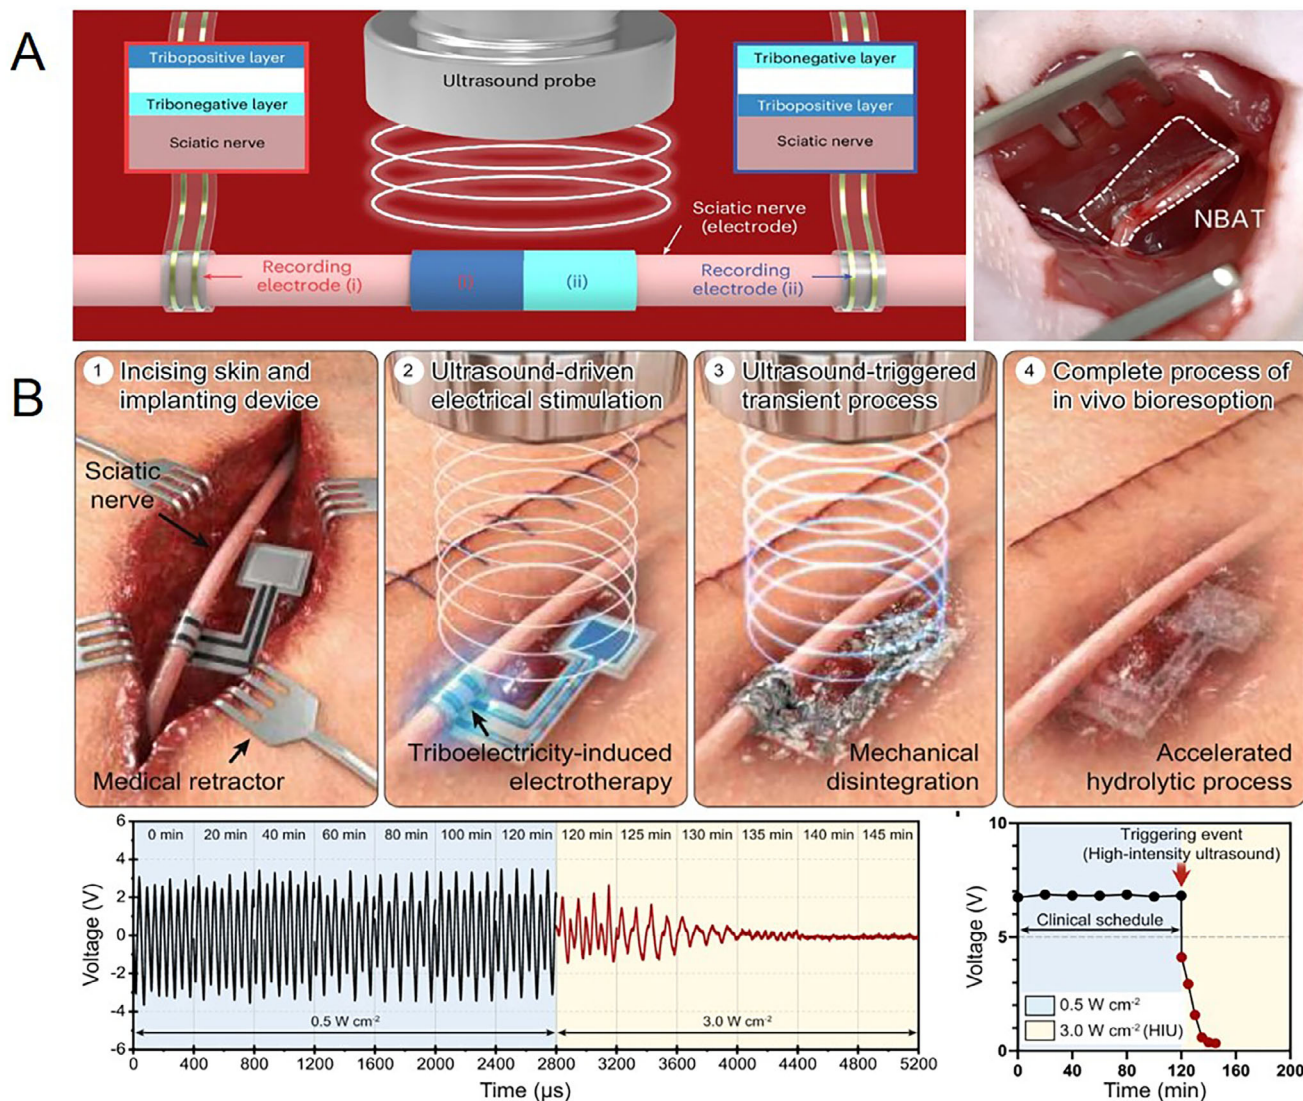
In situ therapeutic applications of implantable triboelectric systems. (a) A bioresorbable TENG that generates localized triboelectric electric fields under ultrasound stimulation for pain modulation. Reproduced with permission [42]. Copyright 2026, Springer Nature. (b) An ultrasound-activated TENG-based neural stimulator capable of stimulating the sciatic nerve, enabling wireless and on-demand neuromodulation in vivo. Reproduced with permission [62]. Copyright 2023, Springer Nature.
